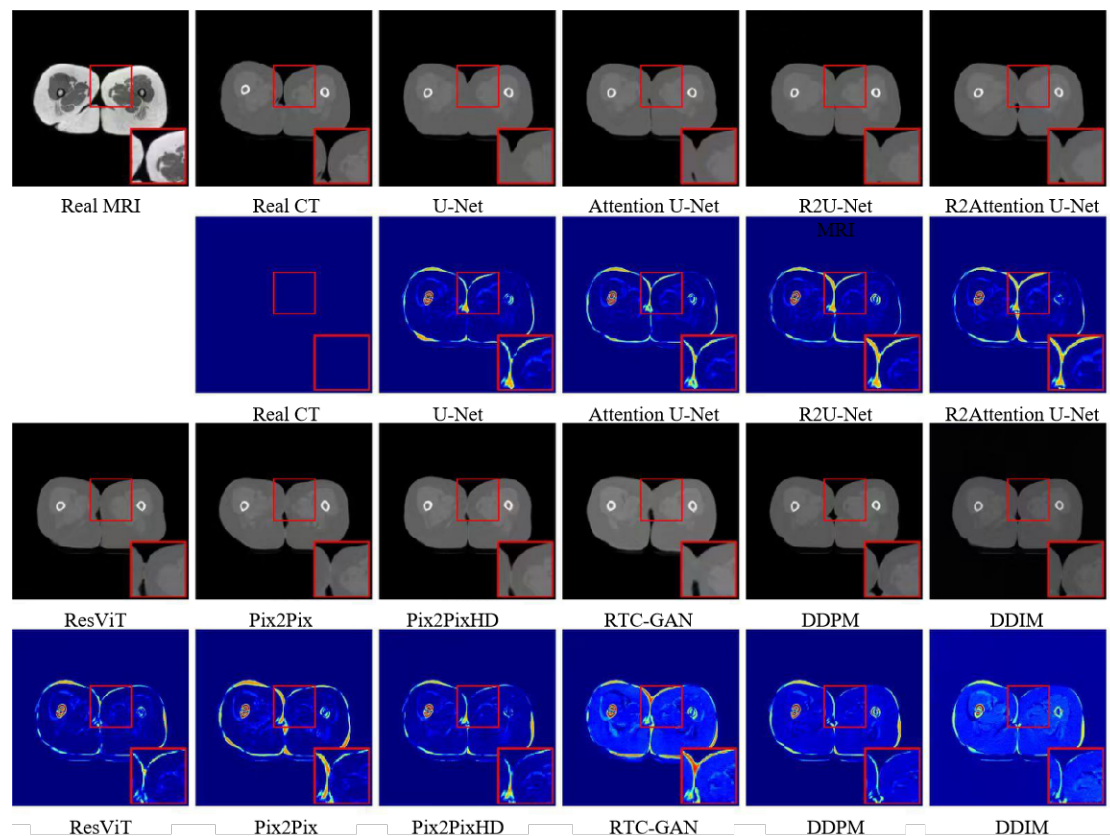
Representative sCT results from different model families under a unified experimental setting. The same MR input and reference CT are used for all methods. Red boxes indicate enlarged local regions for detailed visual comparison. The error maps show the absolute difference between the generated CT and the reference CT.
